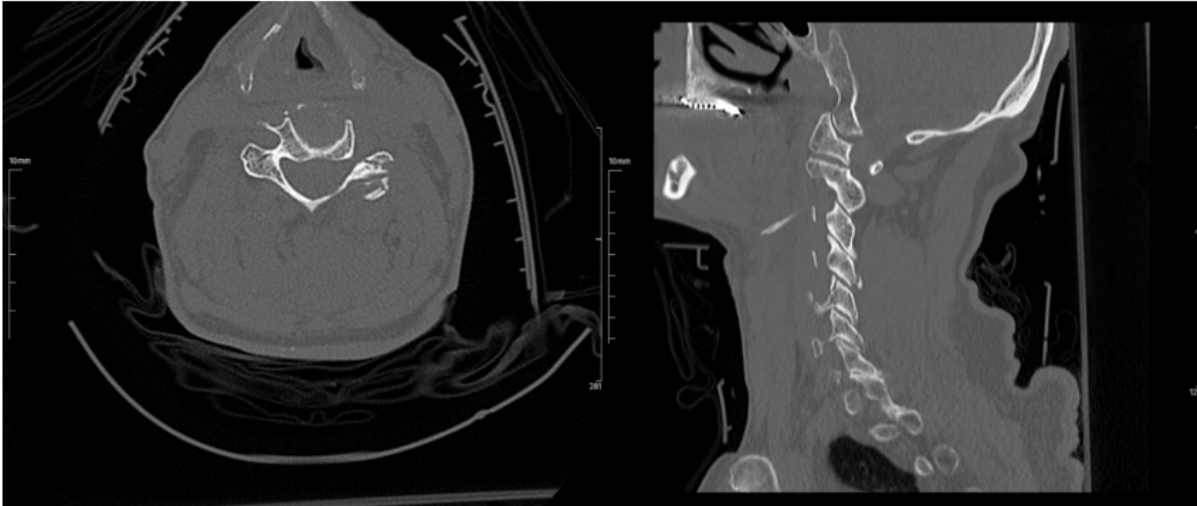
Cervical computed tomography imaging of the first patient showing fractured lamina of the fifth cervical vertebra
